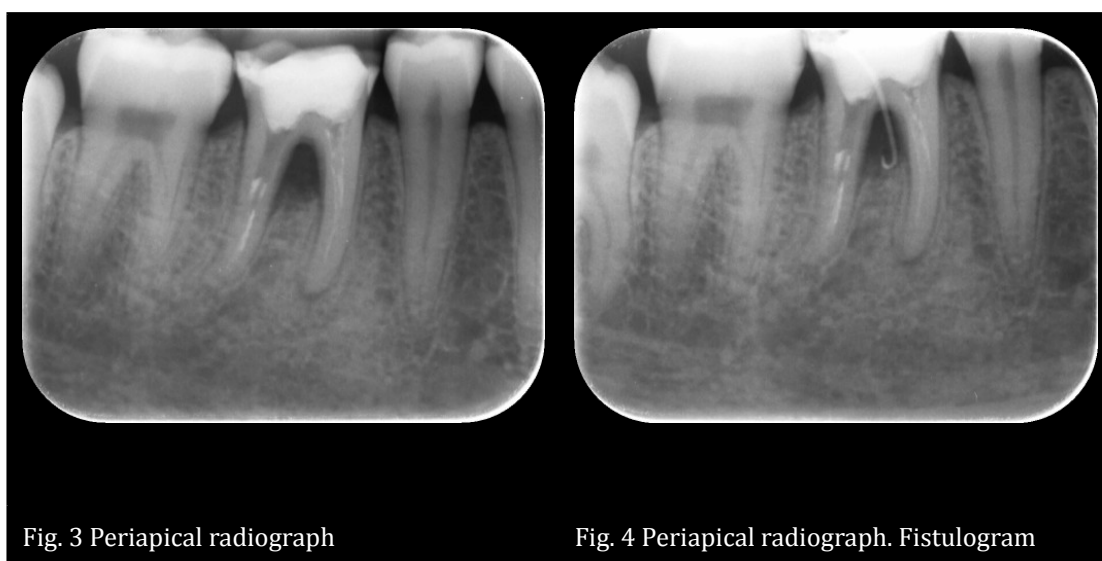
Periapical radiograph
